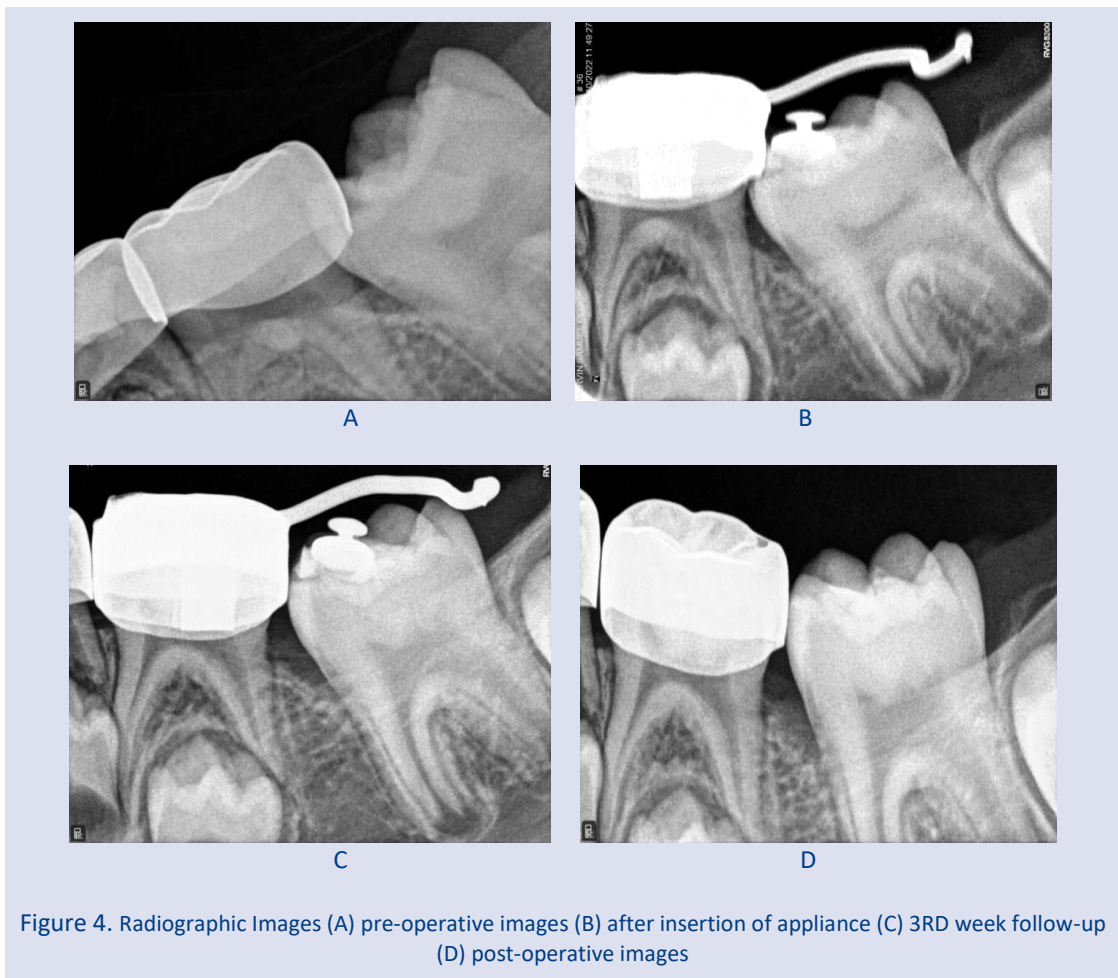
Radiographic Images (A) pre-operative images (B) after insertion of appliance (C) 3RD week follow-up (D) post-operative images
